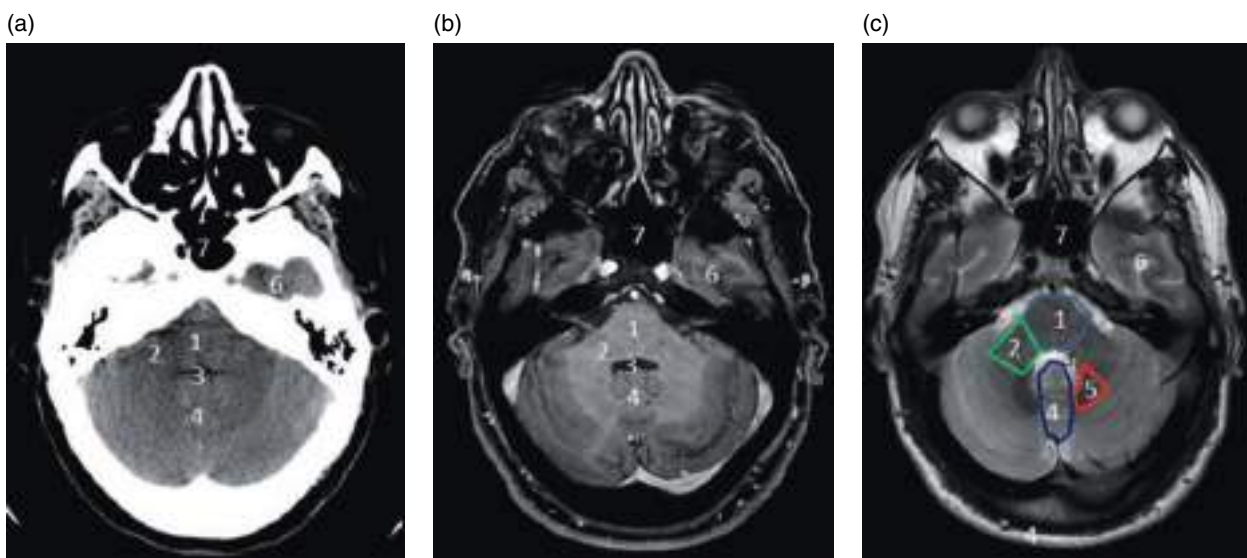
Infratentorial axial anatomy, sections at the level of the fourth ventricle. (a) Axial noncontrast CT image. (b) Axial contrast-enhanced T1-3D-weighted MRI. (c) Axial TSE-T2-weighted MRI. 1, pons; 2, middle cerebellar peduncle; 3, fourth ventricle; 4, cerebellar vermis; 5, dentate nucleus; 6, temporal lobe; 7, sphenoid sinus.
